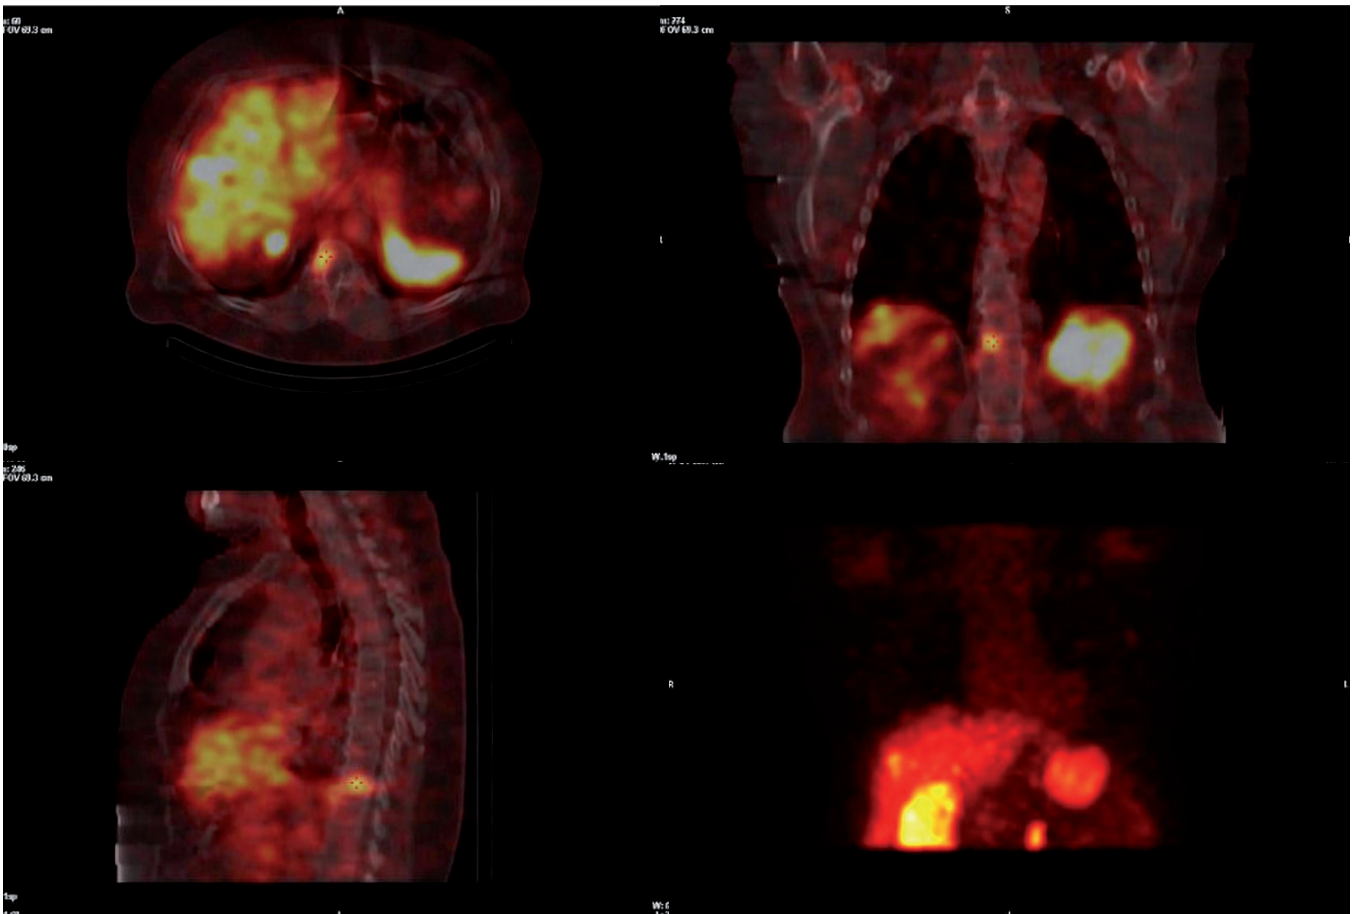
SPECT/CT. Stabilisation of the disease. Pathological overexpression in the liver, mesenteric ileum, at the upper pole of the Th12 vertebra and at the upper pole of the right kidney
